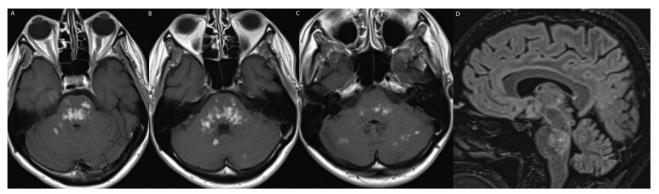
The initial brain MRI: T1-weighted post-gadolinium axial scan (A-C), T2-weighted sagittal scan (D)
